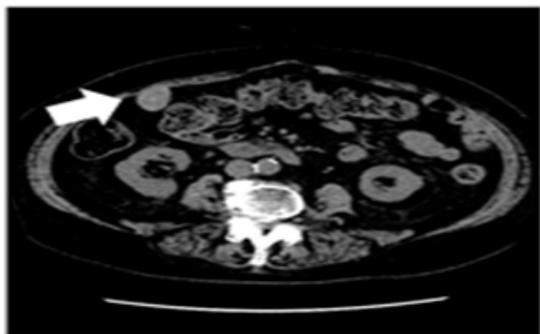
A contrast-enhanced CT scan of the abdomen obtained after 3 cycles a partial response (white arrow) was noted.
